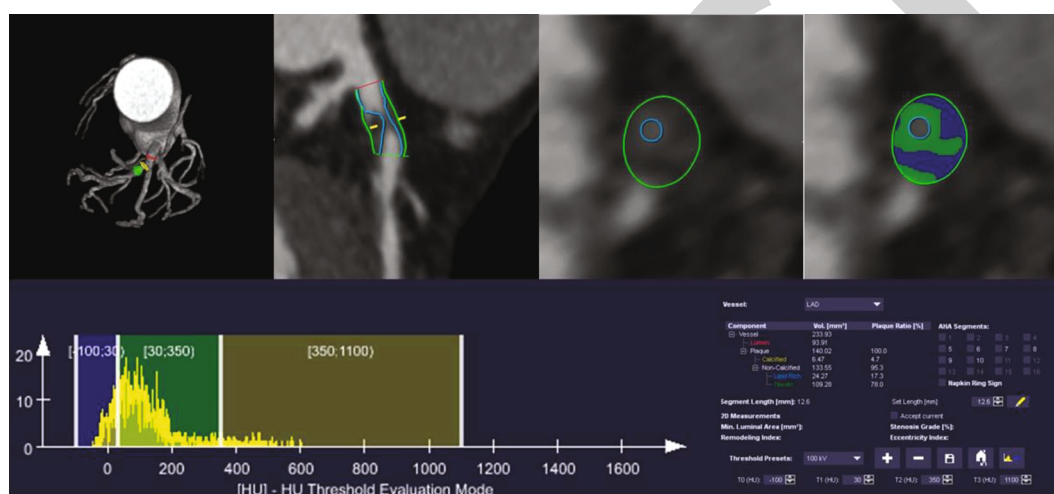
Precise quantitative analysis method for plaque composition based on CCTA images. The vessel and lumen contour were depicted manually. After automatic recognition specific composition CT attenuation, the volume of each composition was calculated. Above case showed a quantitative process of noncalcified plaque located at the proximal segment of left anterior descending branch. The lesion length was 12.6 mm, the lumen volume was 93.91 mm³, the total plaque volume was 140.02 mm³, the calcified volume was 6.47 mm³, the noncalcified volume was 133.55 mm³, the lipid volume was 24.27 mm³, and the fibrous volume was 109.28 mm³.
